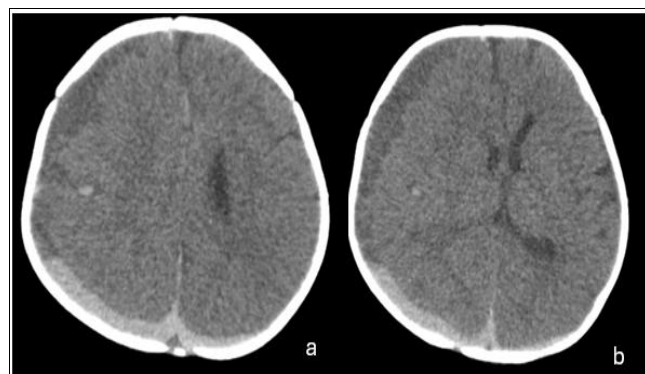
Axial non-contrast CT images of the brain (a, b) demonstrate an acute-on-subacute right frontoparietal subdural hematoma causing significant mass effect with effacement of the ipsilateral lateral ventricle and approximately 5.8 mm leftward midline shift.
